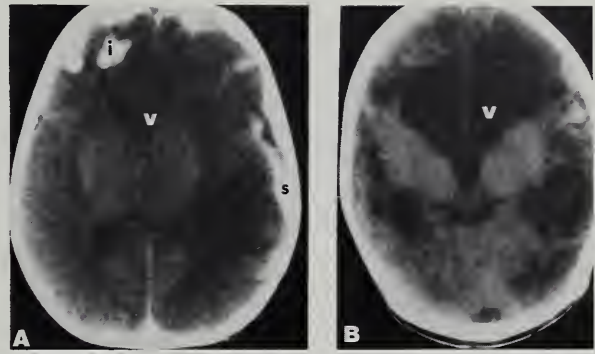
This 3-month male was badly battered. Cranial computed tomography on admission (A) showed intracerebral (i) and subdural (S) hemorrhages with displacement of the normal sized lateral ventricles (V) to the right. A repeat study, one month later (B), showed multiple low density areas throughout both cerebral hemispheres with marked dilatation of the now undisplaced lateral ventricles (V). This demonstrates the severe intracranial injuries that can occur and the extensive permanent brain damage that can result from child abuse.
